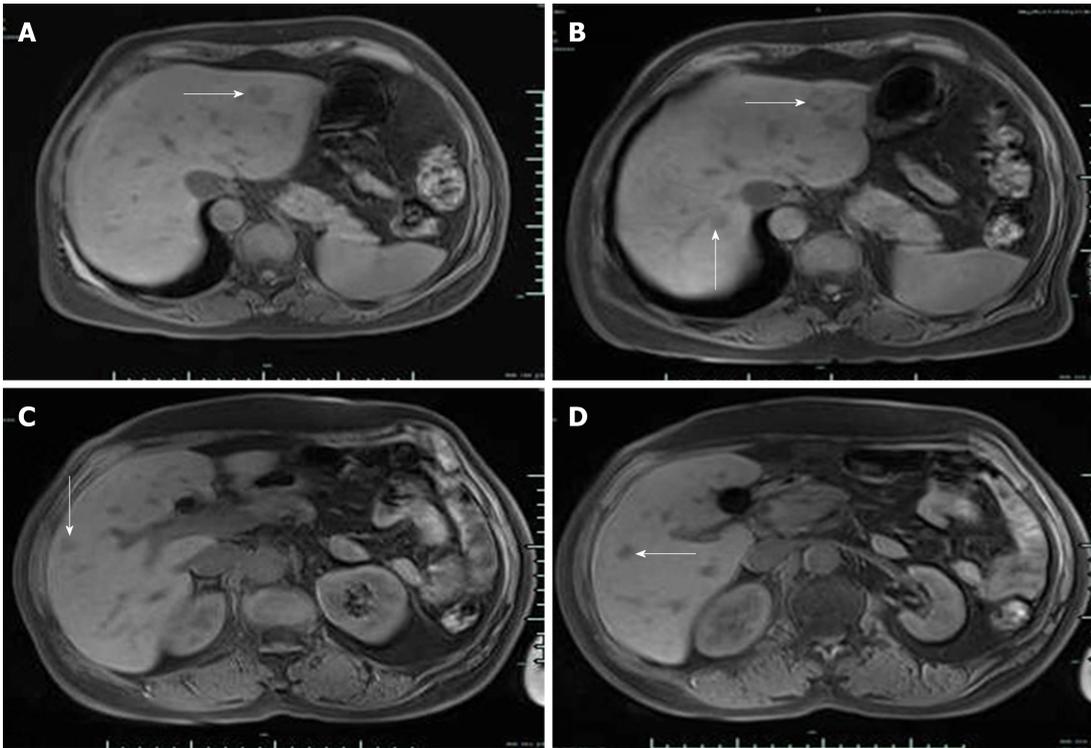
Magnetic resonance images of liver metastases. A: An oval mass in the left liver before transcatheter arterial chemoembolization with a clear boundary and diameter of about 1.9 cm; B, C, D: Magnetic resonance imaging 3 mo after transcatheter arterial chemoembolization revealed no significant reduction in the original metastatic tumor in the left liver and appearance of a new metastatic tumor in the right liver (arrow).
